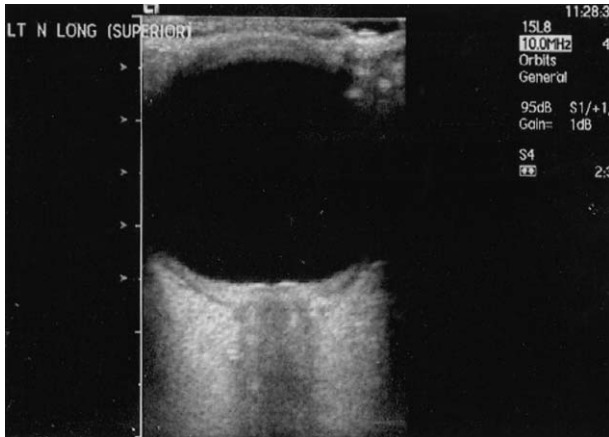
B-scan ultrasound demonstrating posterior scleritis. Note localized thickened area indicating area of posterior scleral swelling.
